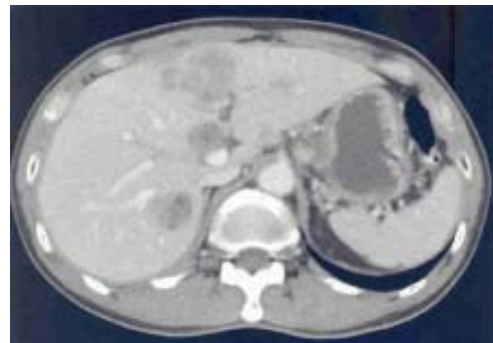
CT scan of the abdomen showing multiple lymph nodes and liver involvement. There was thickening of the stomach wall.
